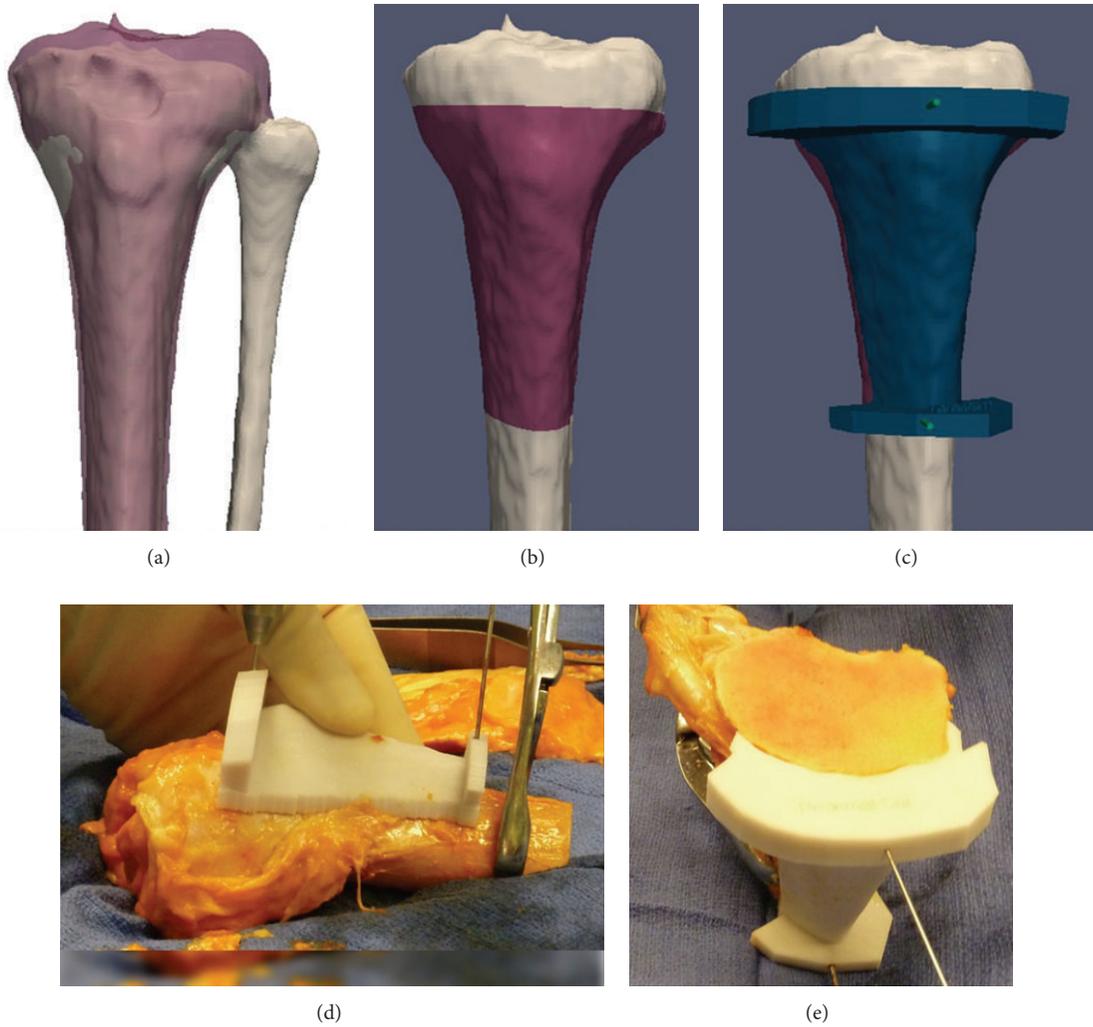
Images from the patient shown in Figures 1 and 2. (a) Merging of the allograft CT and the tibial CT of the patient. (b) Target planes have been transferred to the allograft. The pink zone is the planned cut allograft. (c) A PSI has been virtually created (blue) and is shown pinned to the bone with two K-wires (green cylinders). (d) PSI has been positioned on the surface of the tibial allograft. (e) Allograft after cutting with the saw.
